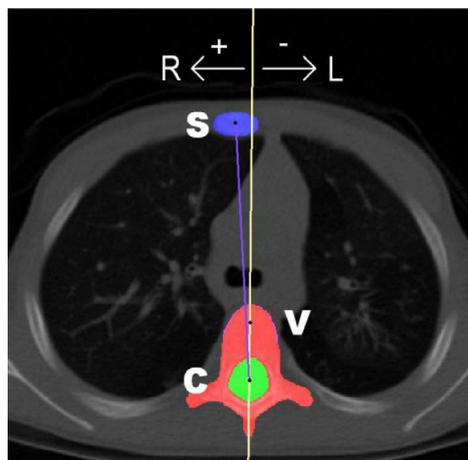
Vertebral rotation - the angle between the longitudinal axis of the vertebra (spinal canal 'C' – center of mass anterior half of the vertebra 'V') and a midline through the thorax (spinal canal 'C' – sternum 'S') - was semi-automatically measured on the transverse slices of CT-scans of normal children.
